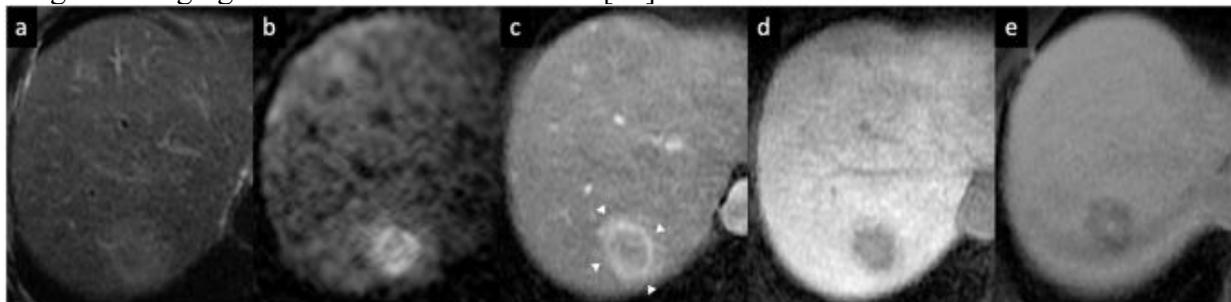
cHCC-CCA tumor in a 55-year-old man with hepatitis C-related cirrhosis. a Gadoxetate disodium magnetic MRI shows a heterogeneous hyperintense lesion on fat-suppressed T2-weighted images, (b) high SI on DWI, (c) contrast-enhanced T1-weighted images demonstrate an irregular rim APHE (arrowheads), and (d) low SI on hepatobiliary phase acquired 20 min after administration of hepatobiliary contrast agent. e On the hepatobiliary phase 2 h after administration of gadobenate dimeglumine, the periphery of the lesion is hypointense, while the central fibrotic areas show high SI (“targetoid appearance”). A biopsy of the liver confirmed the diagnosis of cHCC-CCA [51].
